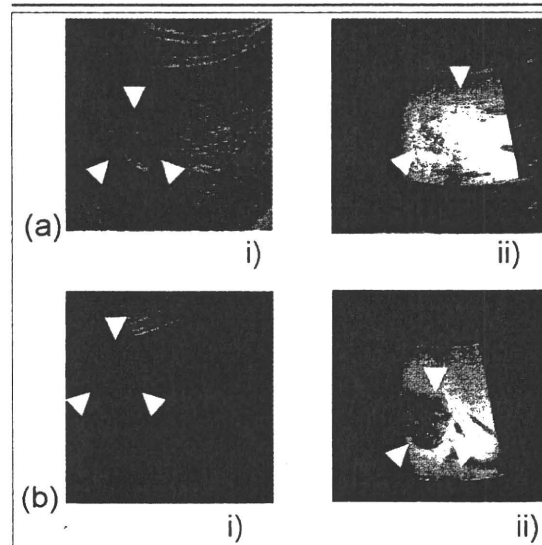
Contrast enhancement of hemangioma at liver-specific phase (a) Type 1 (diffuse enhancement). i) Grayscale. Hyperechoic lesion was seen at segment VIII in the liver (18mm, arrowheads). ii) Contrast-enhanced sonogram of liver-specific phase. The lesion had diffuse enhancement appearance. (b) Type 2 (partial enhancement). i) Grayscale. Hyperechoic lesion was seen at segment VIII in the liver (36mm, arrowheads). ii) Contrast-enhanced sonogram of liver-specific phase. The lesion had partial enhancement appearance.
